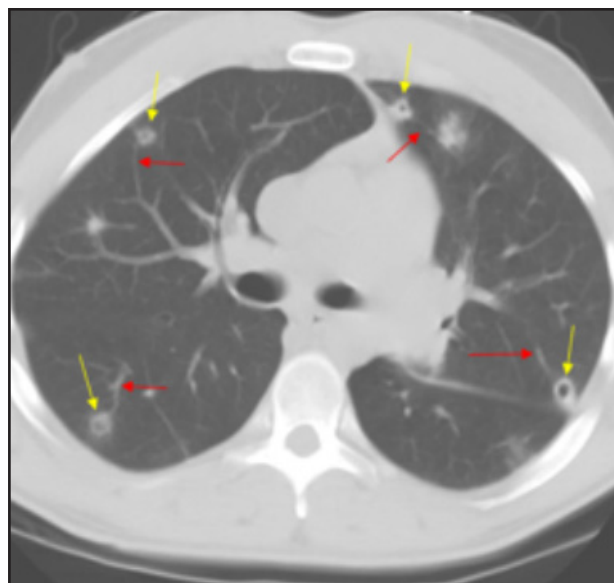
Septic emboli.* Axial contrast-enhanced CT image demonstrating multiple peripheral cavities (yellow arrows) in various stages of evolution with feeding vessels (red arrows).
